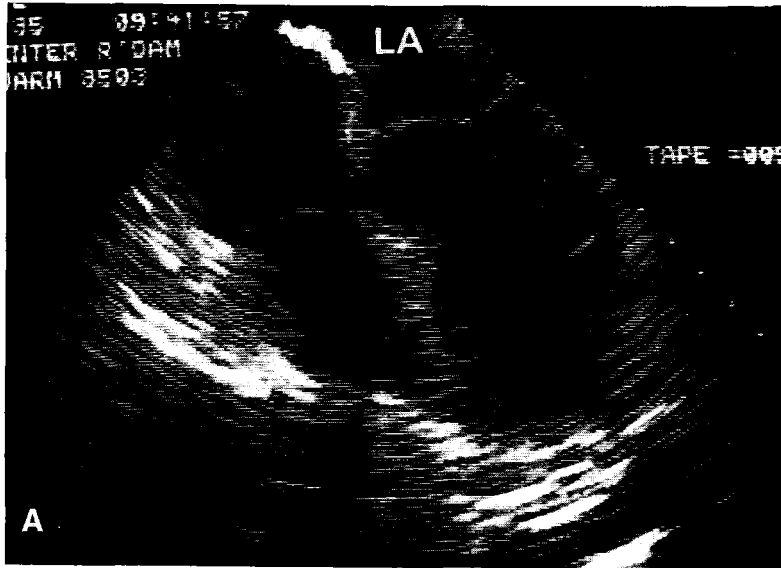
Transesophageal two-dimensional echocardiograms (3 MHz transducer) obtained in a patient with an aortic valve prosthesis and a history of infective endocarditis. A, The four chamber image is normal. B, When the transducer tip is tilted slightly upward a mycotic aneurysm (asterisk) is noted between the left atrium (LA) and left ventricular (LV) outflow tract adjacent to the anterior mitral valve leaflet.
